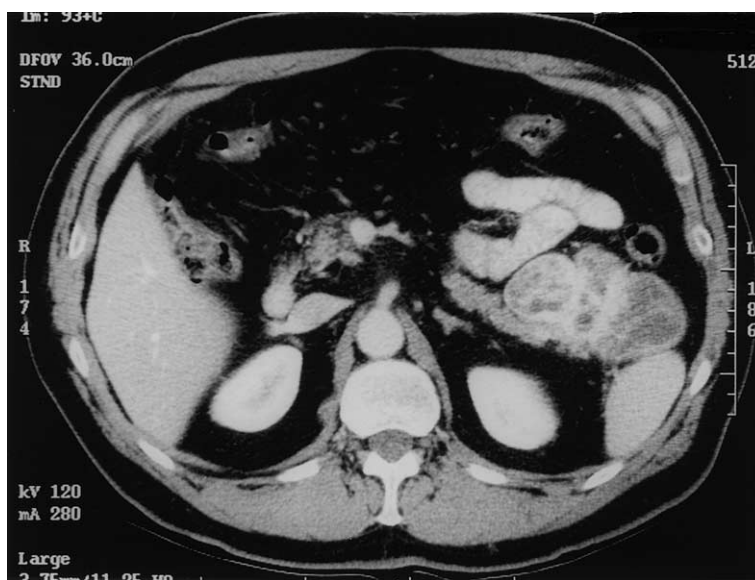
CT scan from case 4 showing multicystic mass originating from the tail of the pancreas.
